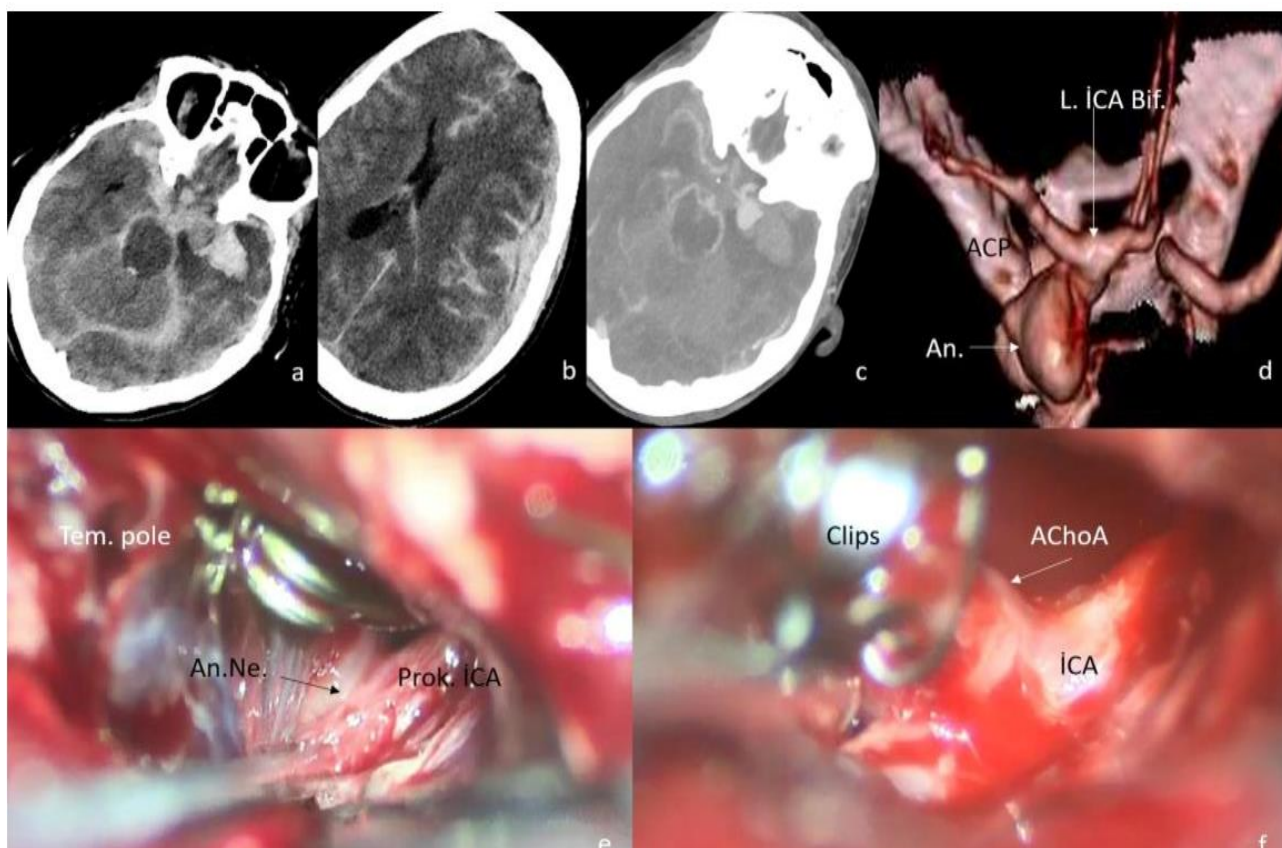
a,b) Initial computed tomography (CT) scan showing diffuse subarachnoid hemorrhage, left temporal intracerebral hematoma, and subdural hematoma in the convexity, c,d) On CT angiography, a 14-mm saccular aneurysm was observed in the anterior choroidal artery (AChoA) extending to the anterior fossa dura, e,f) After emergency surgery, drainage of the hematoma and subdural hematoma, and temporary clipping, the AChoA aneurysm is clipped (patient number, 16)
